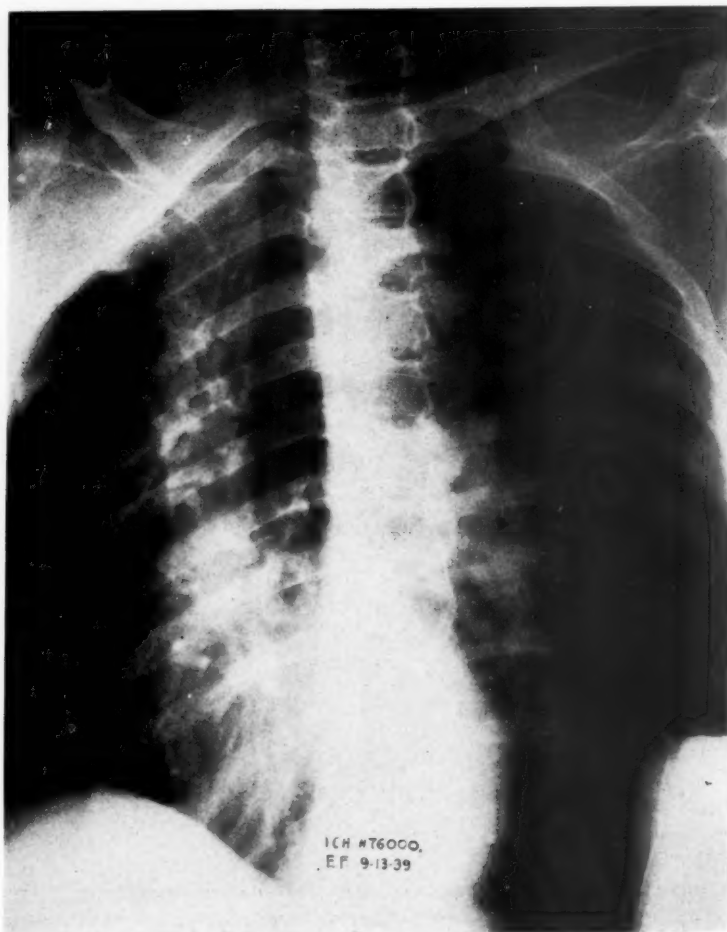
E. F., Sept. 13, 1939. Roentgenogram showing widening and increased density of the aortic shadow.
